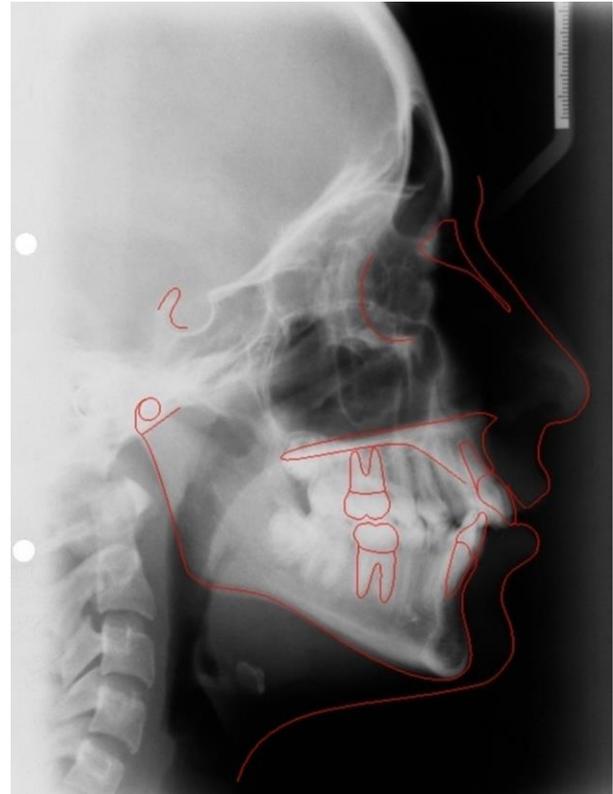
Digitized radiograph
